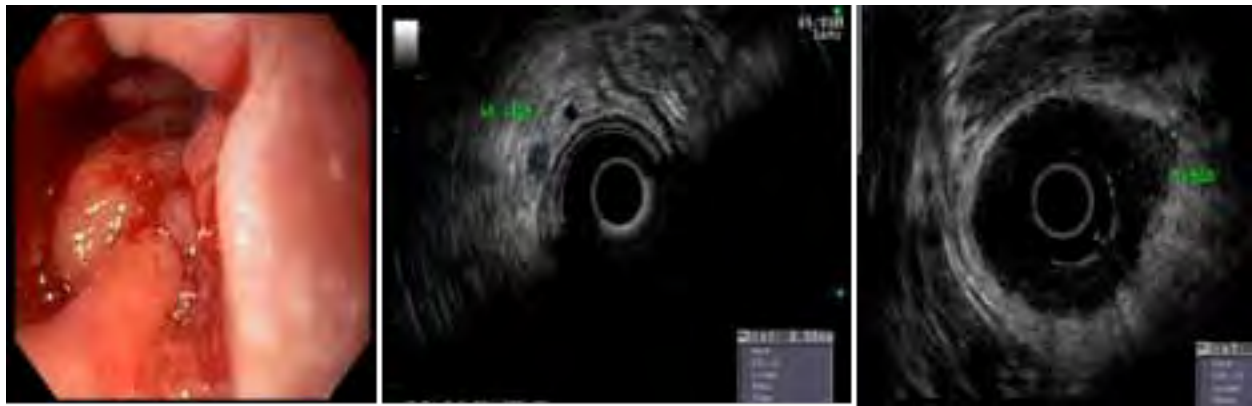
Endoscopy and transrectal ultrasound images of rectal lesion.
